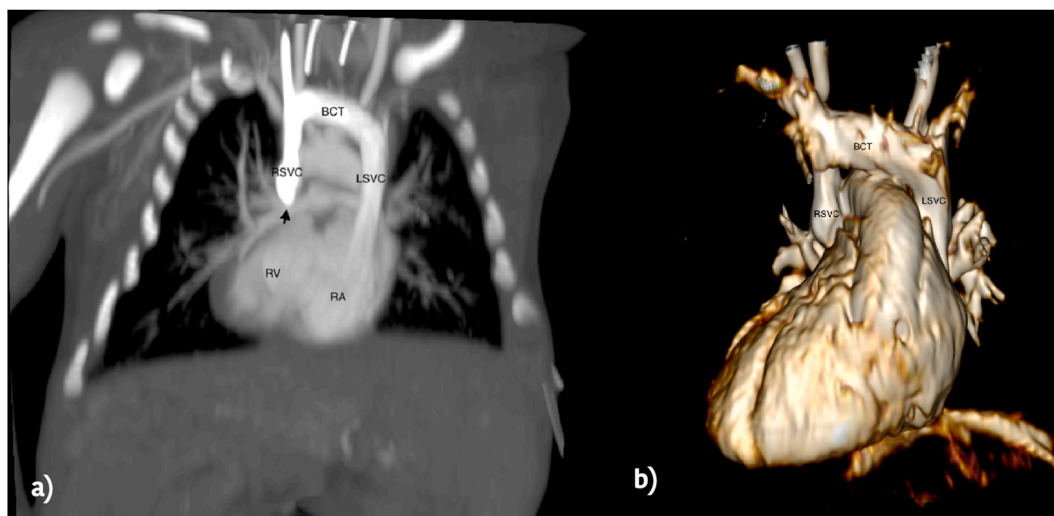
Contrast-enhanced computed tomography para-coronal MPR (a) and VR reconstruction (b) of right SVC interruption and drainage of blood via a persistent left persistent SVC in a patient with left isomerism, dextrocardia and situs viscerum inversus. RSVC = Right superior vena cava; LSCV = Left superior vena cava; BCT = Brachio-cephalic trunk, RA = Right atrium; RV= Right ventriculum.
